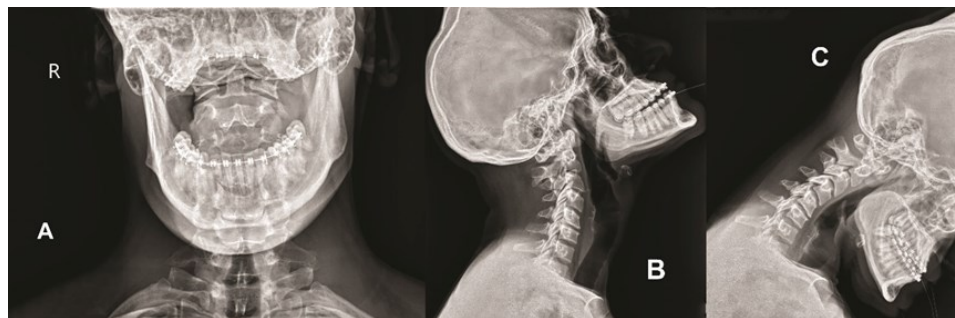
A Open-mouth X-ray of the same patient in figures 3 and 4 after treatment shows significant improvement in atlas rotation relative to the dens. B Lateral X-ray of the patient after treatment in flexion and C in extension showing no anterior/posterior subluxation of the C1.
